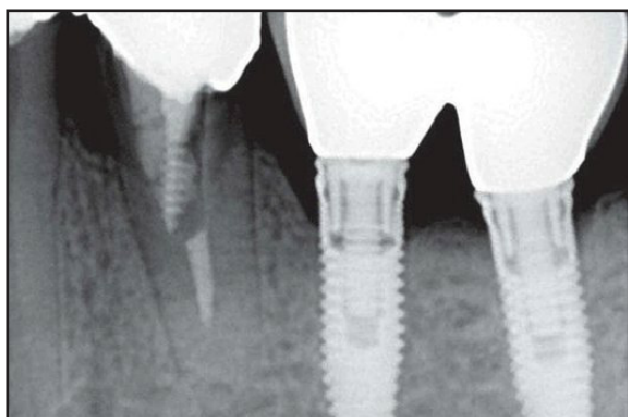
Radiograph of fractured tooth 20.
